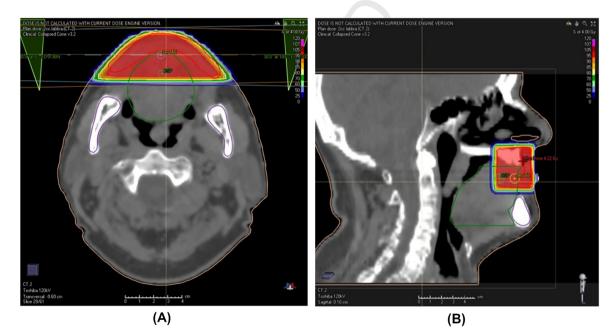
Dose distribution from the radiation treatment plan using two opposite three-dimensional conformal 6-MV photons beam fields in (A) axial and (B) sagittal computed tomography images.
